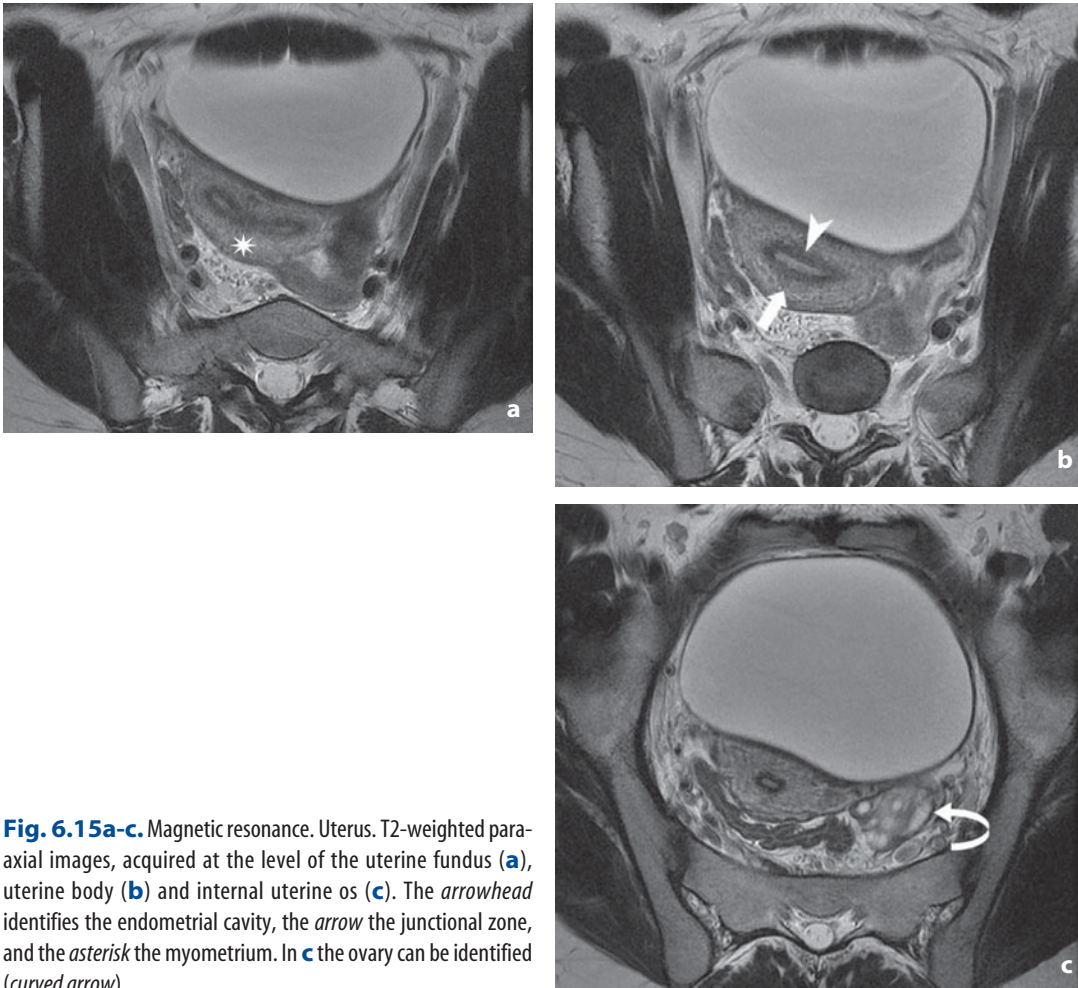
Magnetic resonance. Uterus. T2-weighted para-axial images, acquired at the level of the uterine fundus (a), uterine body (b) and internal uterine os (c). The *arrowhead* identifies the endometrial cavity, the *arrow* the junctional zone, and the *asterisk* the myometrium. In c the ovary can be identified (*curved arrow*)
